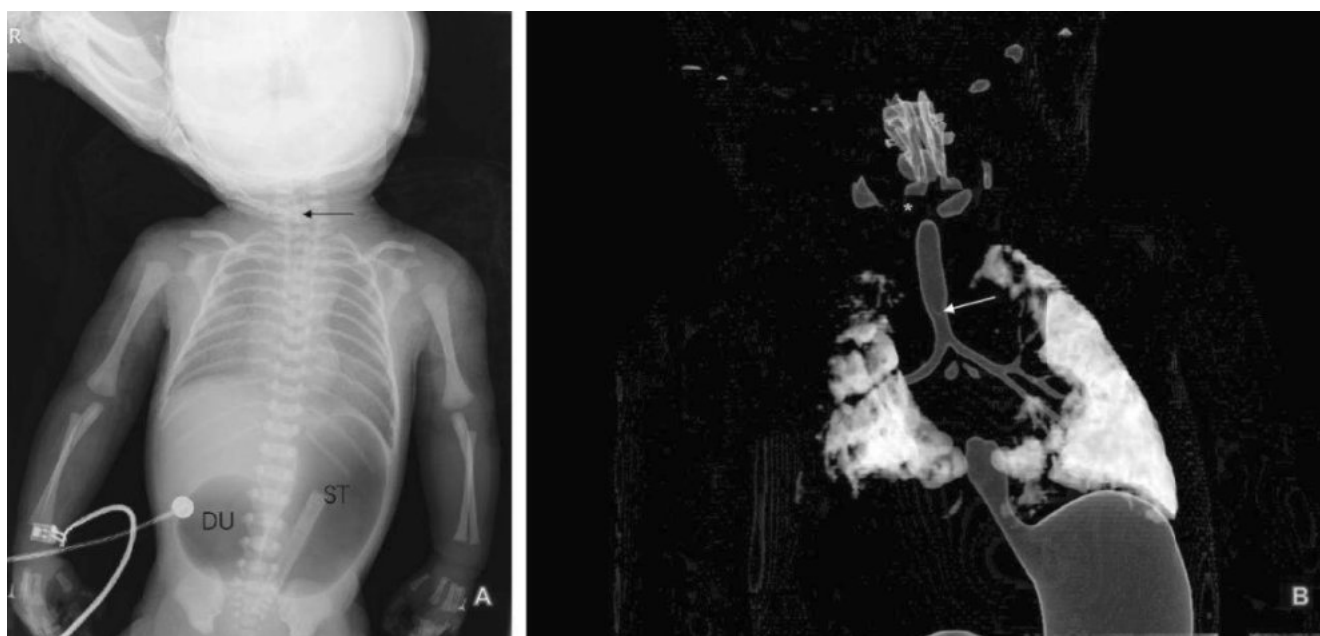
The X-ray and computed tomography scan of the baby showing the tracheal atresia. (A) The X-ray showing the tracheal atresia, and duodenal atresia (Black arrow: the tracheal stylet was located at the glottic opening level; DU: duodenum; ST: stomach) (B) Neck and chest computed tomography scan showing the tracheal atresia and tracheoesophageal fistula (White arrow: there was a suspicious blind end at the distal of the main trachea, while the esophagus above the trachea esophageal fistula was not shown).
